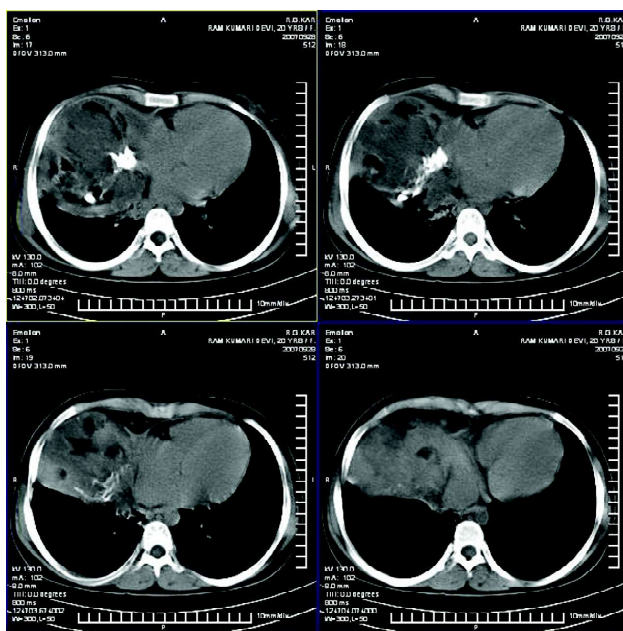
CT thorax showing heterogeneous mass on the right-side.
